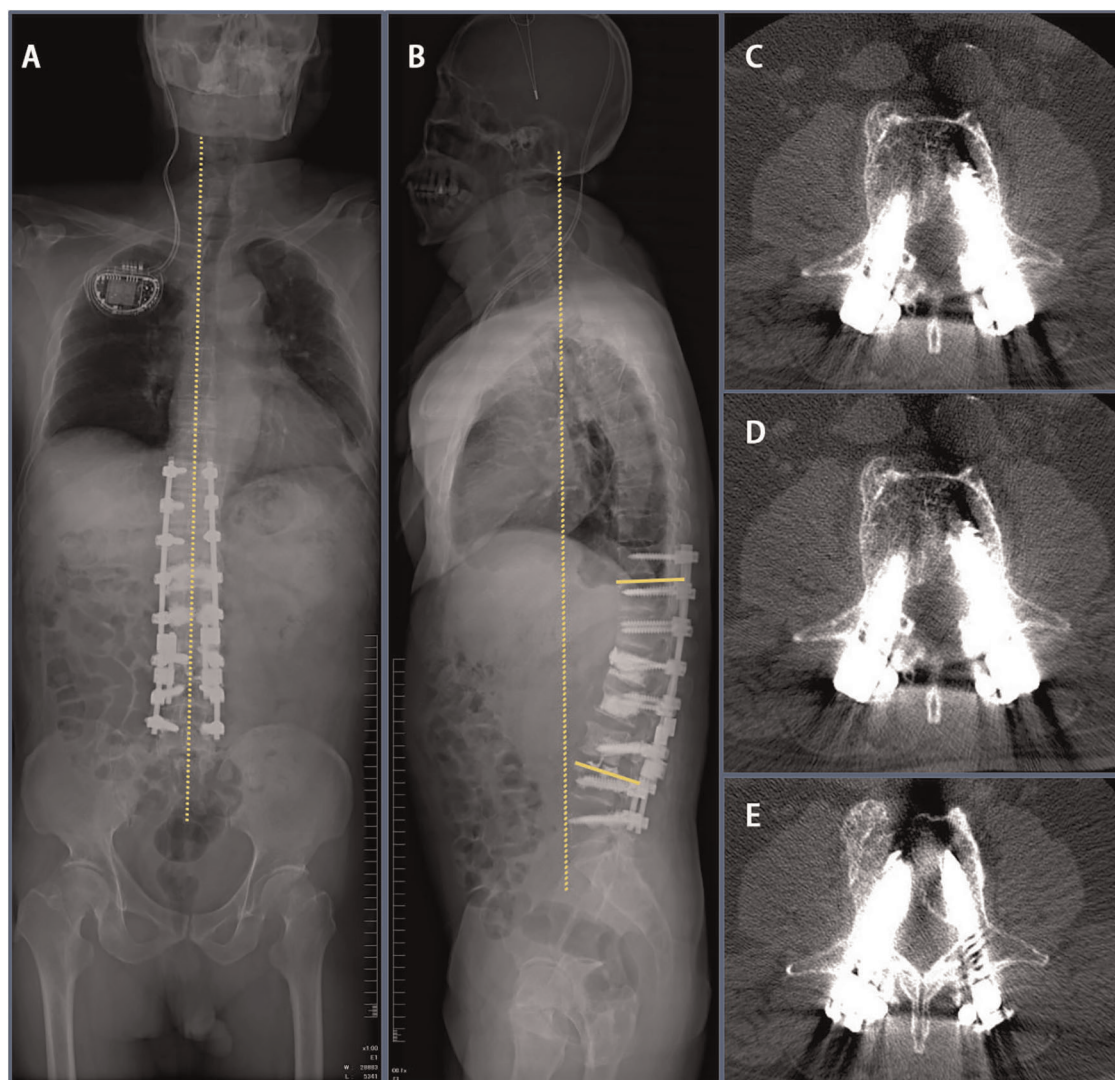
Imaging findings 3 days after revision surgery at our hospital. (A,B) 3 days after revision surgery full-length radiograph of the patient's spine indicated that Cobb's angle decreased to 20°. (C-E) CT scan indicated good internal screw fixation.
